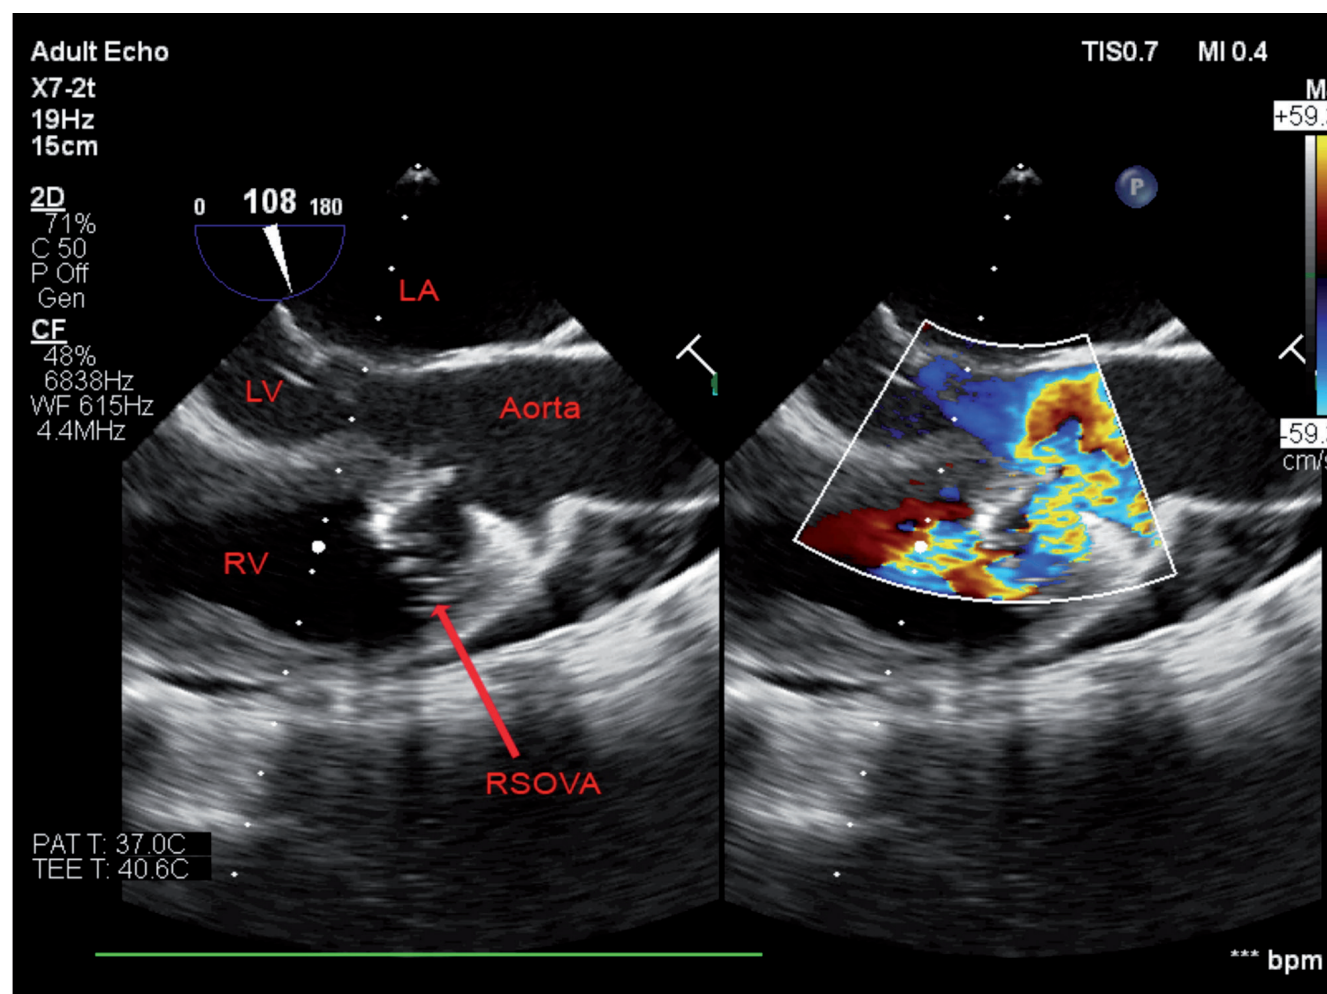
Mid-esophageal long axis view with color doppler demonstrating communication between the aorta and right ventricle with significant left to right shunting of blood. LA, left atrium; LV, left ventricle; RV, right ventricle; RSOVA, ruptured sinus of Valsalva aneurysm.
